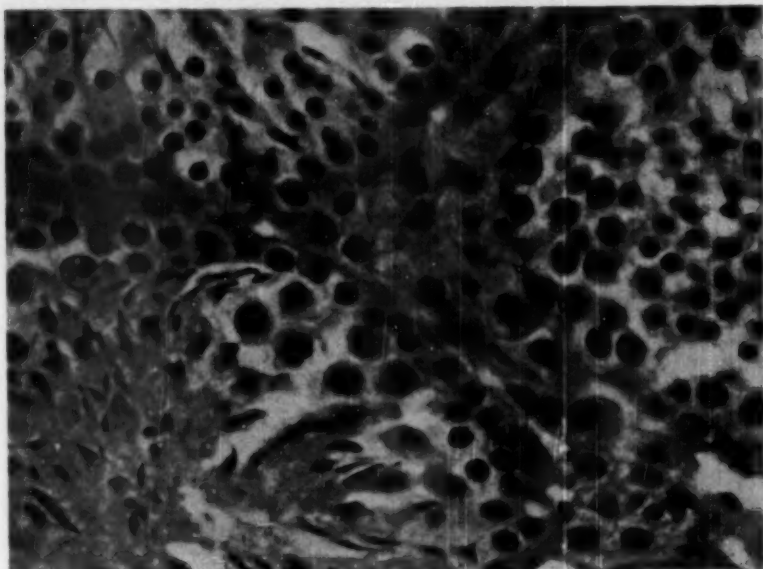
Portions of three representative seminiferous tubules of a testis six weeks subsequent to whole body exposure to 400 r of roentgen radiation. The population, with regard to various stages of spermatogenesis, has returned to normal, although the total numbers are probably less than normal in view of the observation that the weight of the testis was much less than normal. $\times 700$.
